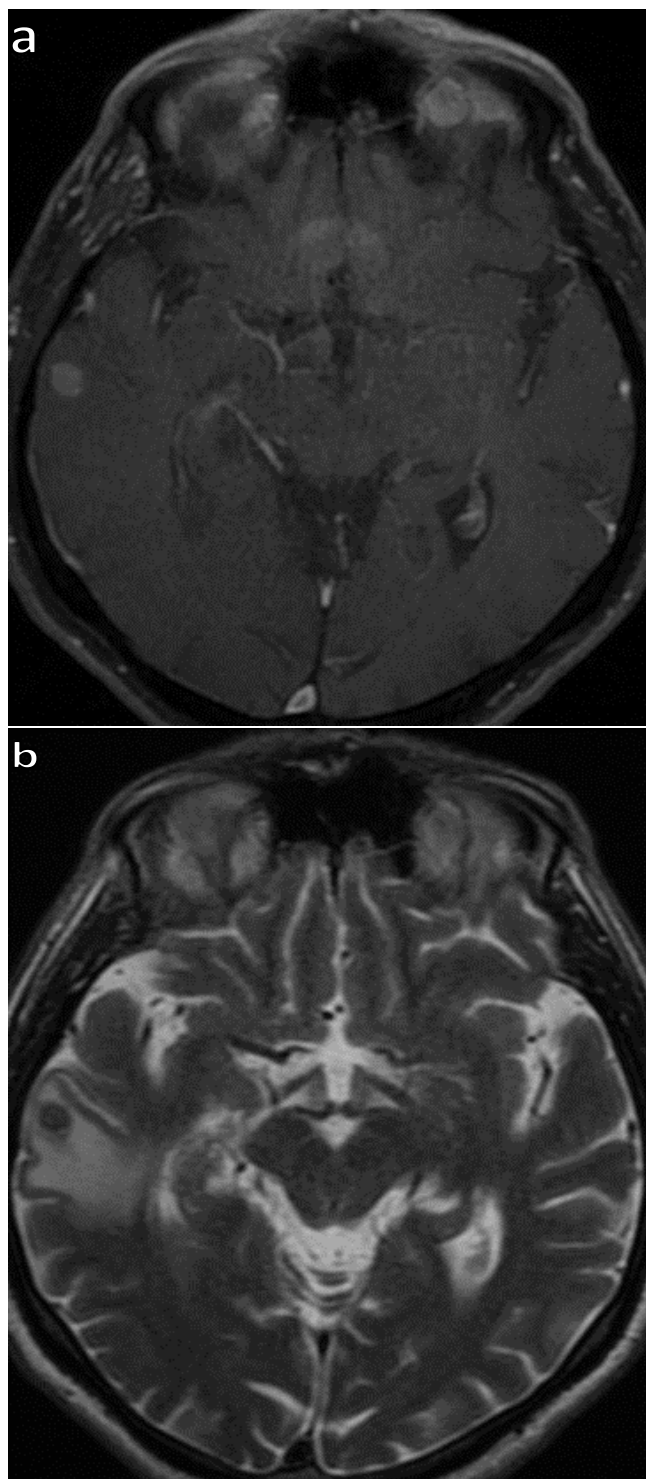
Mass lesion with contrast enhancement in the middle temporal gyrus of the right temporal lobe measuring approximately 9 mm in diameter, suggestive of metastasis, surrounded by vasogenic edema on cranial MRI T1-2 scan
